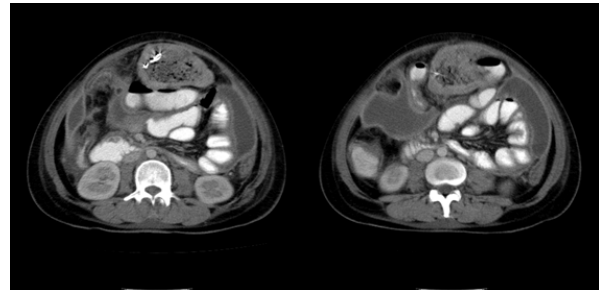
CT SCAN of a patient showing a well-circumscribed mass with thick walls; with internal air foci and few hyperdense linear areas of calcification, showing enhancement of the wall after administration of contrast. The internal structure appears whirl-like or spongiform due to the presence of gas trapped in the mesh of sponges. Associated well defined loculated ascites is also seen with mild peritoneal thickening and enhancement adjacent to the described mass.
